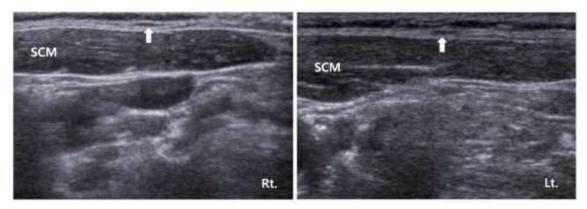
Transverse view on ultrasound depicting the right and left great auricular nerve (arrow) above the sternocleidomastoid muscle, showing a slightly enlarged GAN on the symptomatic left side.
